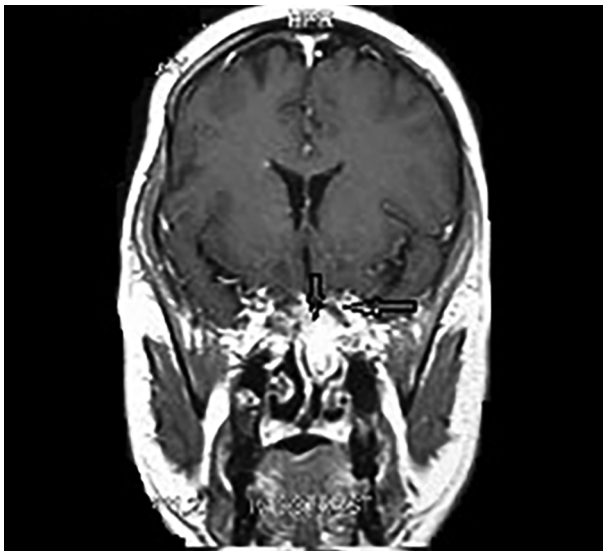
Coronal MRI with Gadolinium enhancement shows an enhanced mass in the left sphenoid sinus (vertical arrow) with some adhesions to the internal carotid artery (horizontal arrow).
